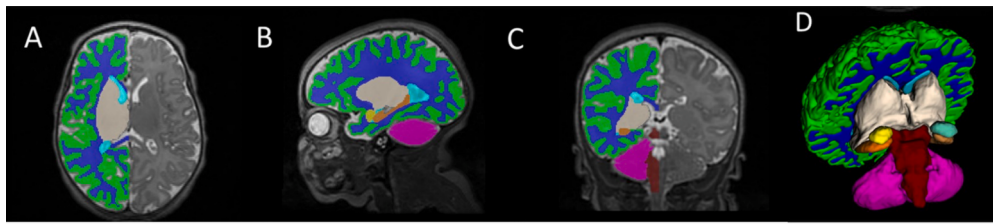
Representative image of newborn brain MRI scan and segmentation in the axial (A), sagittal (B), and coronal planes (C), with resulting 3D segmentation (D). Segmented regions of interest are color-coded as: cortical gray matter (green), cerebral white matter (blue), subcortical gray matter (grey), left amygdala (cyan), right amygdala (yellow), left hippocampus (brown), right hippocampus (orange), cerebellum (fuchsia).
